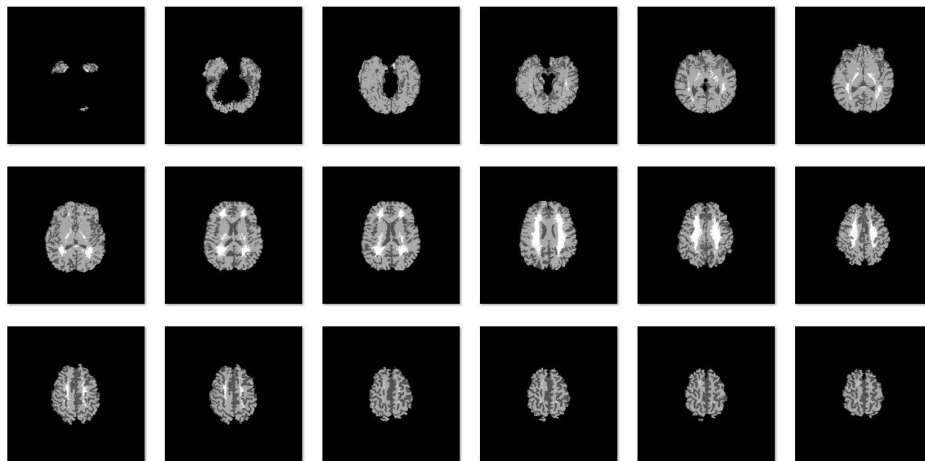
A set of raw segmented MRI scans containing CSF, GM, and WM tissue.
